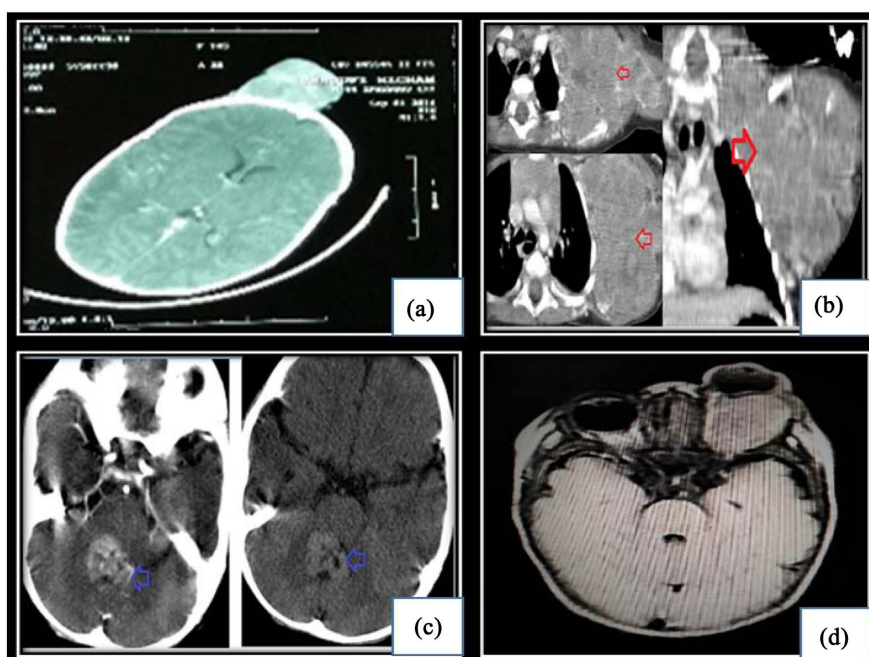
Computed tomography imaging: (a) Subcutaneous tissue lesion, polylobed with calcifications, without bone involvement. (b) Bulky left axillary mass, lobulated, heterogeneous, extending to the cervical region (red arrow). (c) Vermian tissue lesion, spontaneously dense, heterogeneously enhanced, extended to the right cerebellar hemisphere (blue arrow). (d) Left intra-conical retro-orbital tumor process responsible for proptosis.
